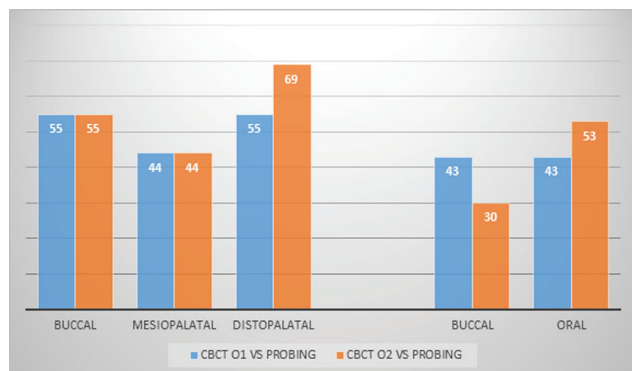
Agreement in percentage between clinical (probing) and CBCT assessment for both observers, according to the site in maxillary molars (buccal, mesiopalatal, distopalatal) and the site in mandibular molars (buccal, oral)
